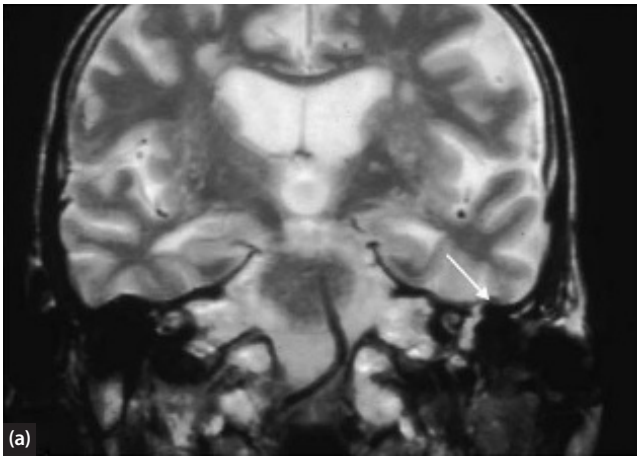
(a) Pre-operative coronal T2-weighted image demonstrating a tegmen CSF leak. Arrow shows site of leakage. (b) Post-operative coronal CT scan demonstrating bone pate repair. Arrow shows site of repair.
